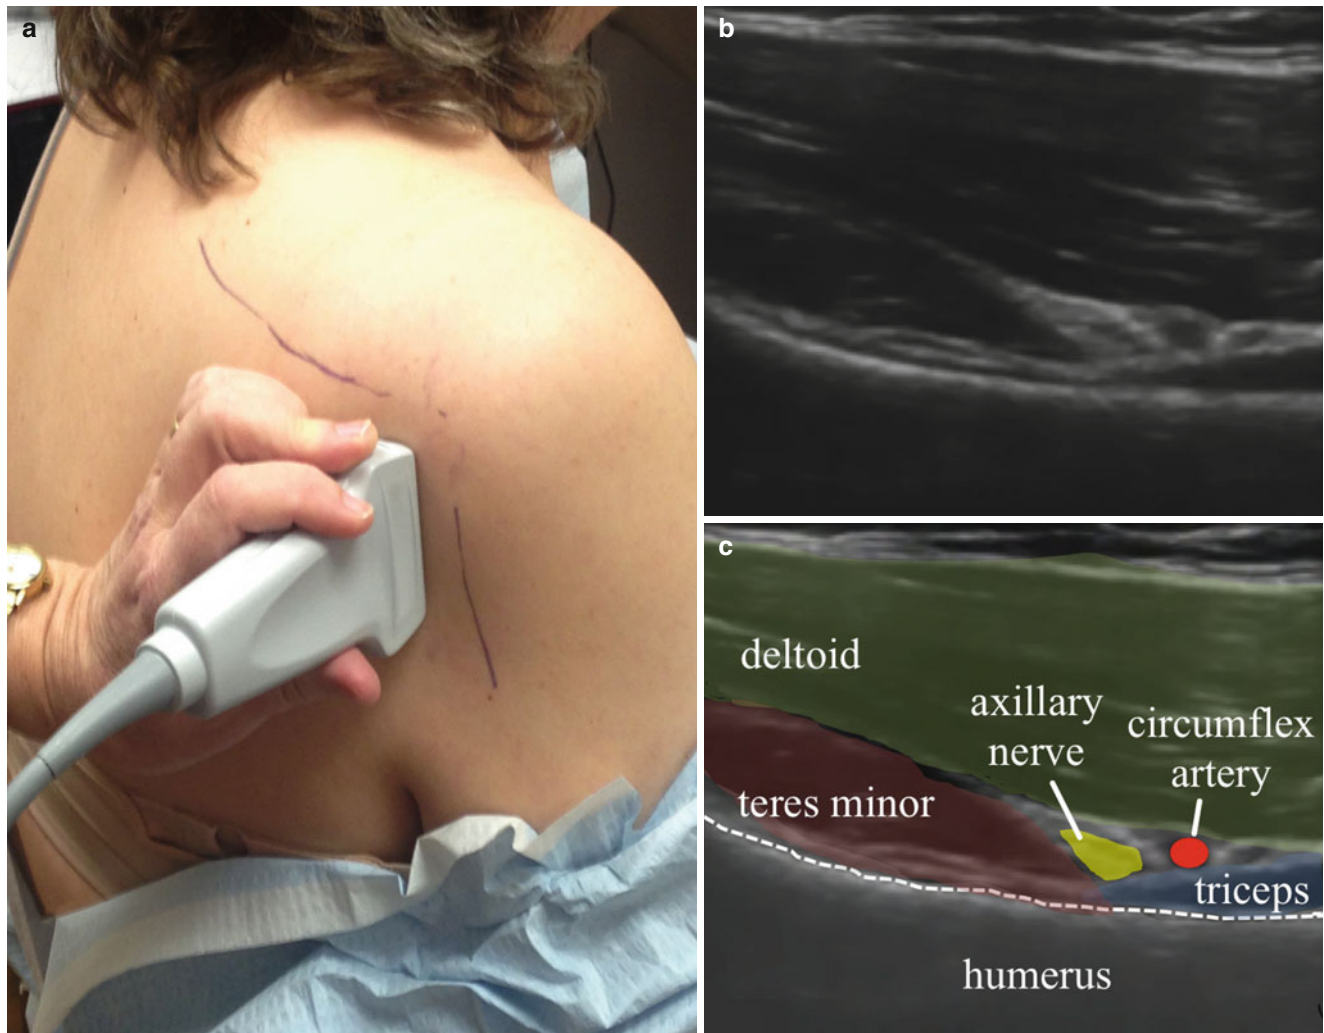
Ultrasound image of the axillary nerve. (a) Location of probe and needle direction, (b) ultrasound image of axillary nerve, (c) labeled ultrasound image (Image courtesy of Andrea Trescot, MD)
